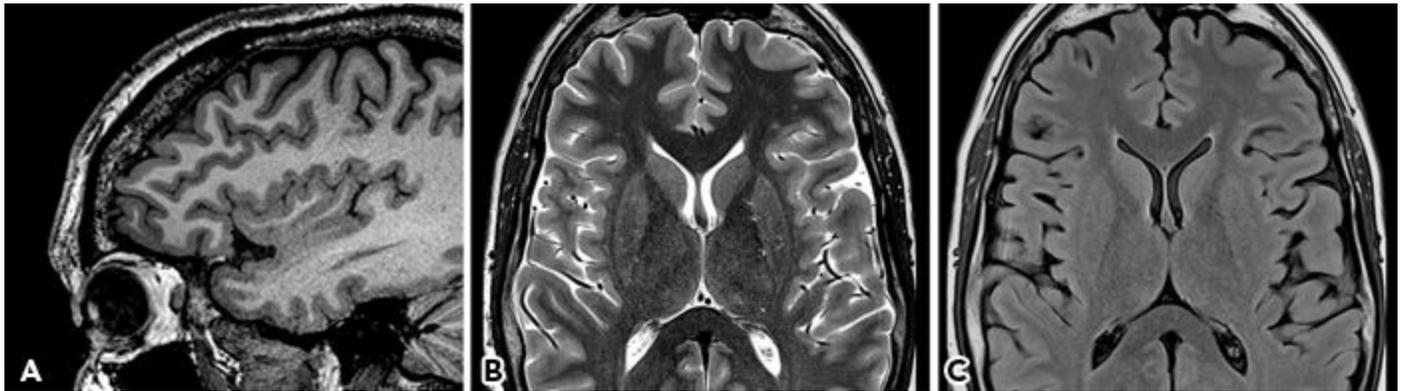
MRI with surface coils placed over the frontal regions yield high-resolution images of the frontal lobe. Deeper structures farther from the coil (temporal structures on sagittal image and basal ganglia on axial images) are poorly visualized due to decreased signal-to-noise ratio.
